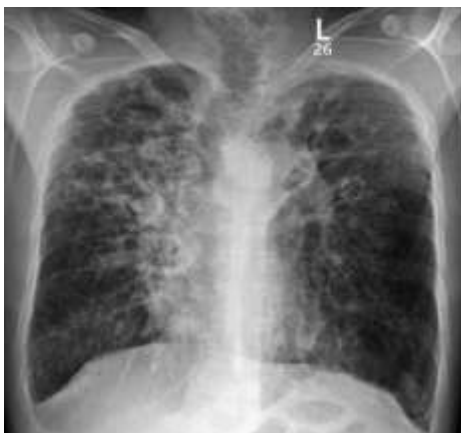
AP Chest X-ray showing dilated trachea and main bronchi with bilateral diffuse interstitial lung markings, nodular shadows and bronchiectasis.
